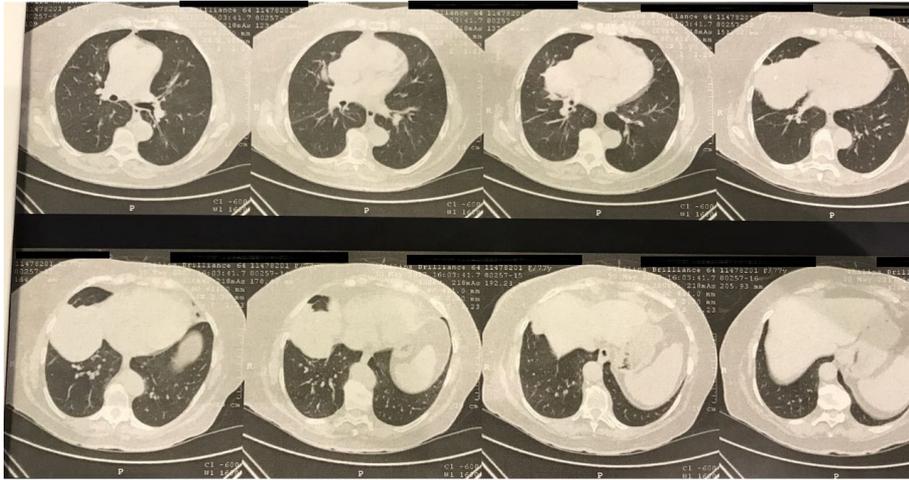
Sagittal chest CT scan
